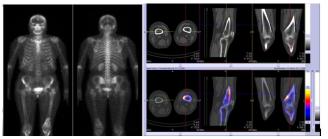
Whole body PET – CT Scan – and knee section of PET-CT scan – activity of the polychondritis.
